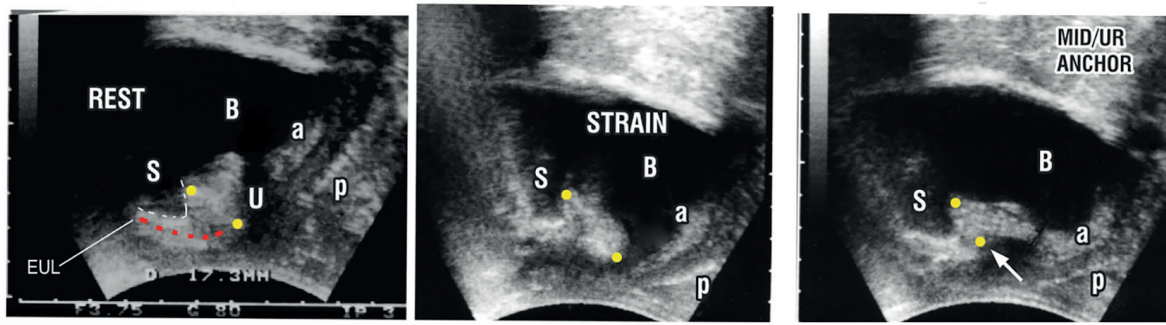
Transperineal ultrasound of a woman with SUI4
